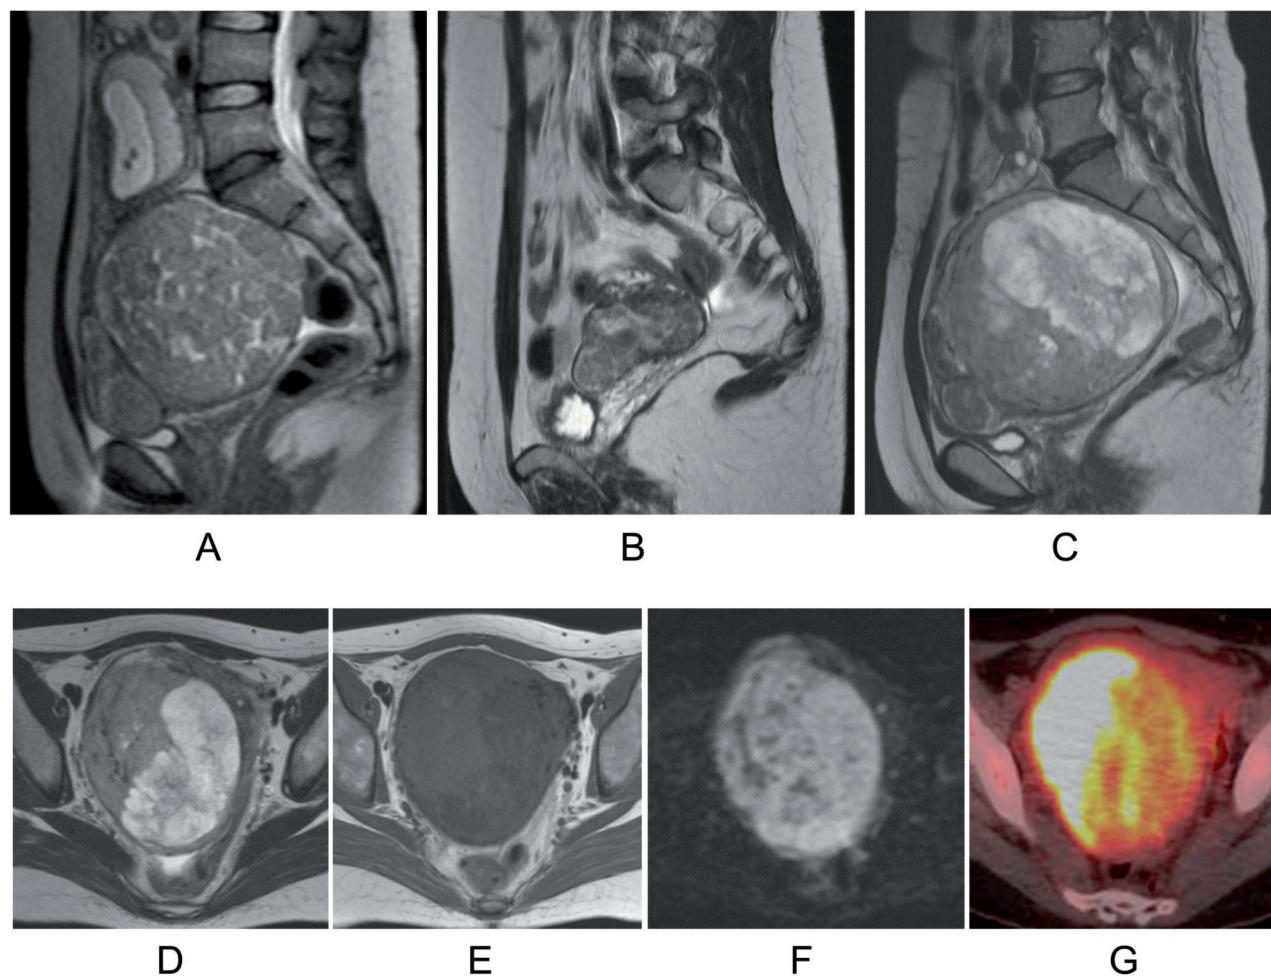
(A) T2-weighted sagittal MRI scans obtained during pregnancy six years ago and (B) two years prior to referral show that a large mass with typical imaging of uterine leiomyoma, located immediately dorsal to two small leiomyoma, regressed dramatically after pregnancy. (C) T2-weighted sagittal MRI scan obtained after referral shows a well-circumscribed mass, located immediately dorsal to two small leiomyoma in the same position as the regressed uterine leiomyoma. (C, D) The mass consists of two components with intermediate and high intensity on T2-weighted imaging, with (E) small areas of high intensity on T1-weighted imaging (arrows), and exhibits (F) diffuse high intensity on diffusion-weighted imaging. (G) Positron emission tomography-computed tomography image showing intense fluorodeoxyglucose uptake (standardized uptake value max: 23.6).
